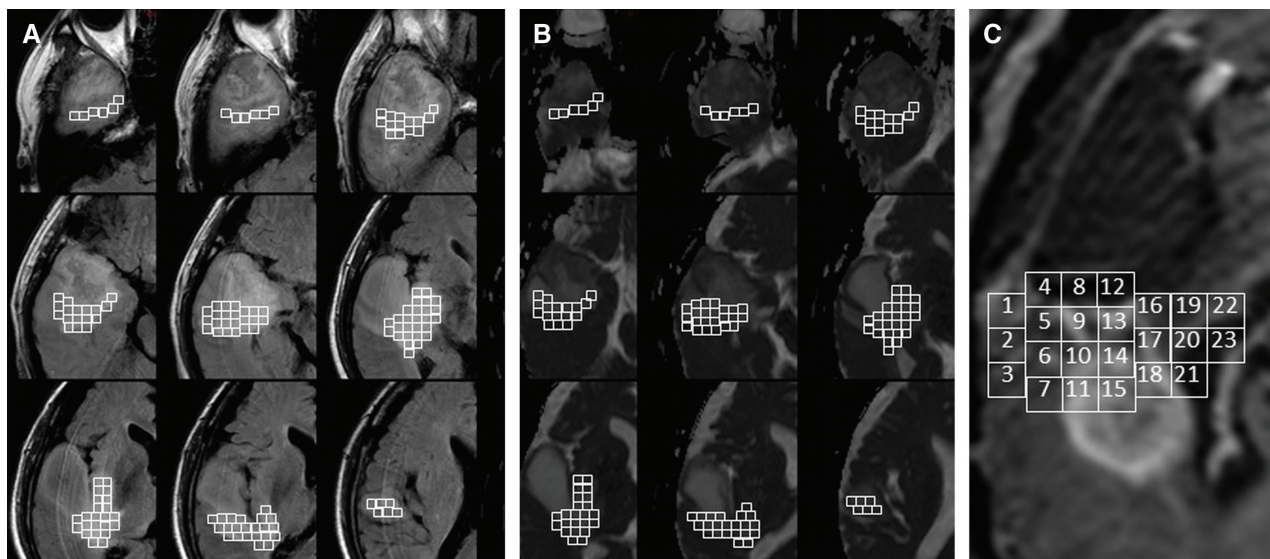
Representative analysis of ADC values on FLAIR high-signal lesion. (A) In this case, a total of 144 ROIs were set in the FLAIR high-signal lesion around enhanced tumor in preoperative MRI. (B) The ADC value was calculated at the ROIs on ADC map corresponding to that of FLAIR images. (C) The fates of ROIs were determined on follow-up MRI with recurrence. There were three categories in plotted numbers: recurrent (9–11, 13–15, and 16–18), stable (1–3, 5–7, and 19–23), and removed (4, 8, and 12). ADC: apparent diffusion coefficient, MRI: magnetic resonance imaging, ROIs: regions of interest.
